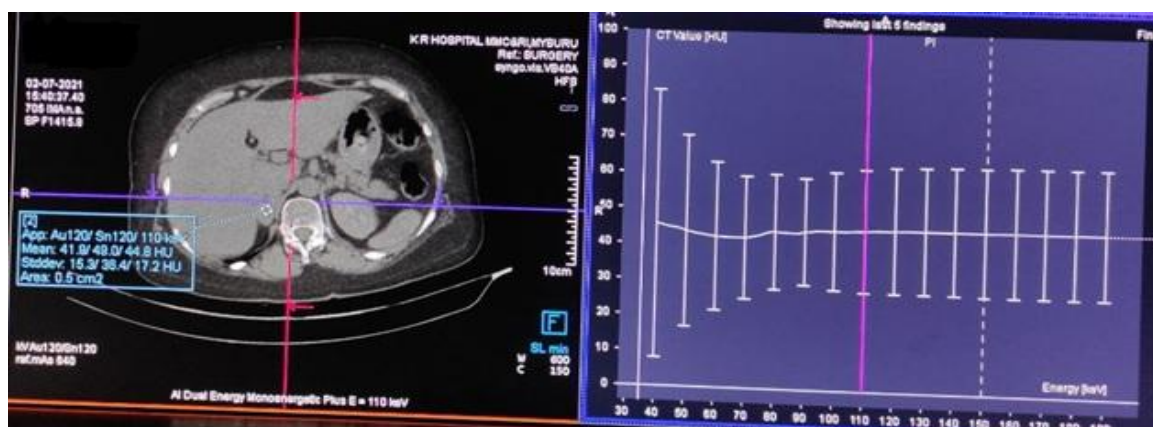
Transverse unenhanced monochromatic (70 Kev) dual energy CT image shows adrenal lesion with image on right showing attenuation values decreasing as photon energy increases, diagnostic of metastases
